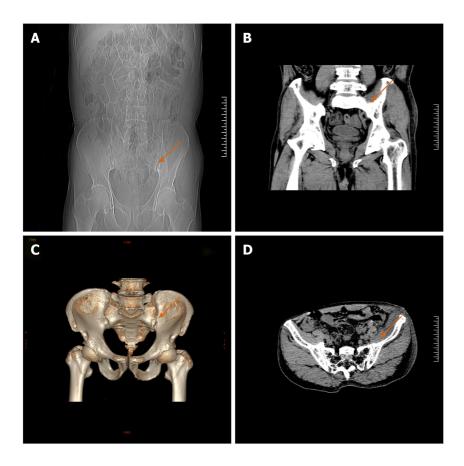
Pelvic computed tomography scan plus 3D reconstruction after the operation. A: Anteroposterior radiograph of the pelvis; B: Coronal computed tomography scan showed the osteophyte has been removed; C: 3D reconstruction showed that the osteophyte from the anterior lower part of the left sacroiliac joint has been completely removed and the articular surface was flat while the osteophyte of the right was still existing, as indicated by the orange arrow; D: Horizontal scan of the pelvic after surgery.
